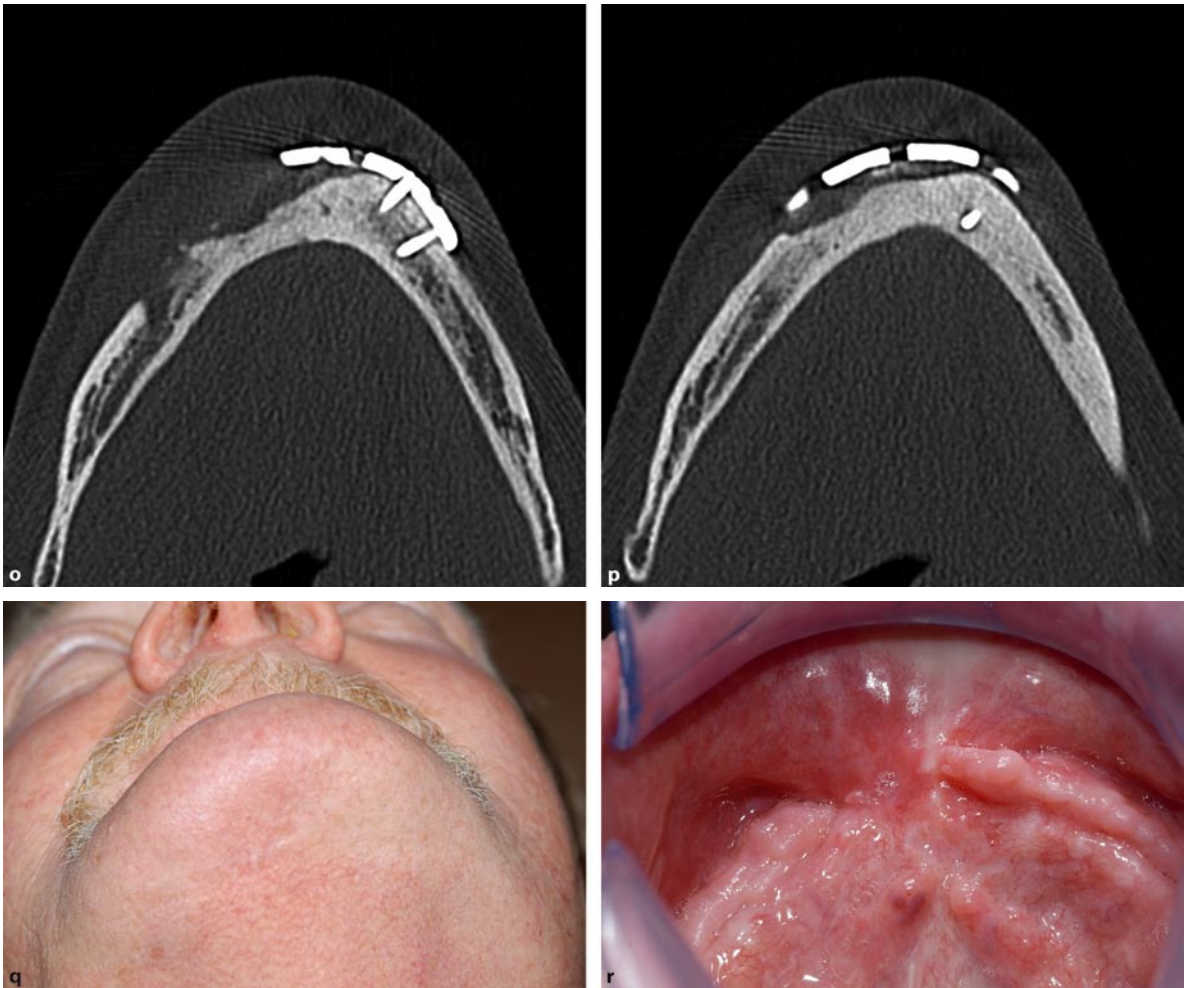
r (*continued*) No signs of residual infection are noted on conventional imaging. On the CT scans residual sclerosis and partial regeneration of bone can be determined. Patient 6 months after surgery (q-r). There is
